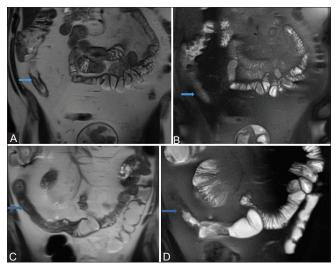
(A-D): (A) Coronal T2-weighted single-shot fast spin-echo image of the anterior abdomen without fat suppression shows a focal segment of bowel wall thickening with loss of normal fold pattern and T2 hyperintense signal, which may be secondary to acute edema or chronic fat deposition in the wall (arrow). (B) Coronal T2-weighted single-shot fast spin-echo image of the anterior abdomen with fat suppression shows persistent high T2 signal (arrow) within the same featureless bowel loop, indicating that this is due to edema, which corresponds to active disease. (C) Coronal single shot fast spin echo image of the anterior abdomen with T2 signal (arrow) within a bowel loop. (D) Coronal fat suppressed T2 weighted image of the anterior abdomen shows loss of high T2 signal (arrow) within the same bowel loop, indicating that this is due to chronic fat deposition
